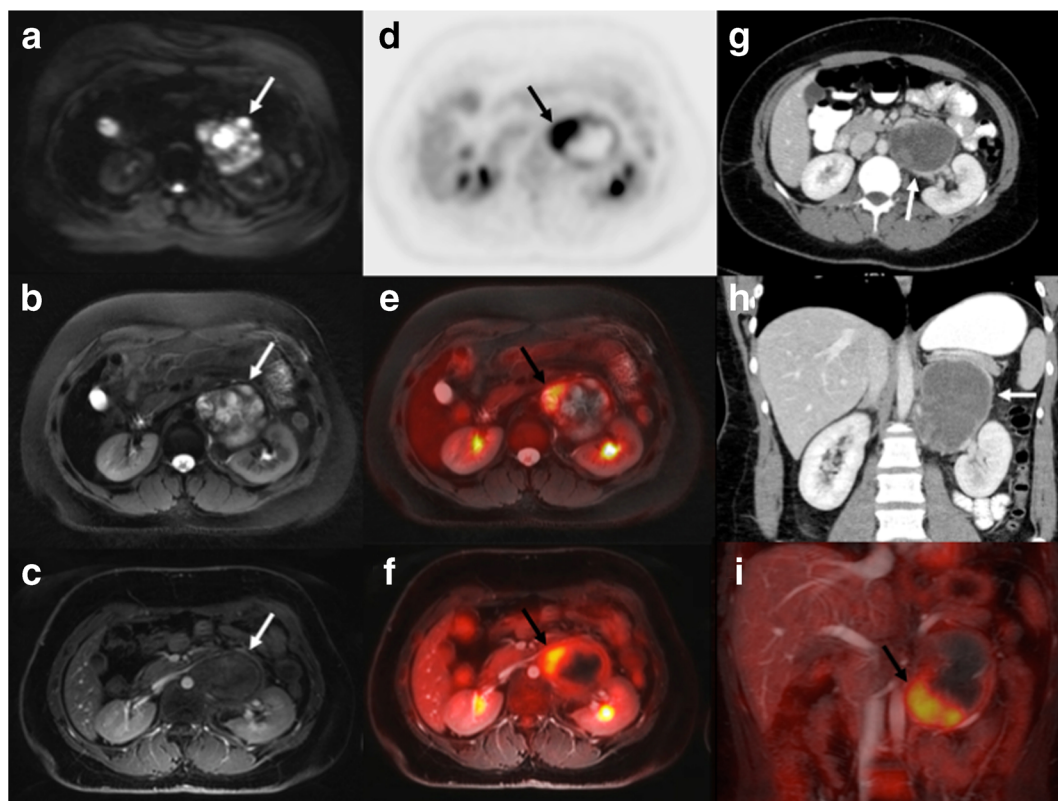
[^{18}F]FDG PET/MR and CT findings in a 25-year-old female with soft tissue sarcoma in the left retroperitoneum (arrows). a Axial diffusion weighted imaging (TR/TE/b-value: 7770/56.1/50,600) shows restricted diffusion (white arrow) of the tumor. b Axial T2 PROPELLER (TR/TE/Flip angle: 8000/95.8/142) shows inhomogeneous hyperintense tumor signal. c Ferumoxytol-enhanced T1-weighted LAVA scan (TR/TE/Flip angle: 4.2/1.7/15) shows close relation between the tumor and renal vessels. d Axial [^{18}F]FDG PET, e [^{18}F]FDG PET superimposed on T2-weighted PROPELLER scan, and f [^{18}F]FDG PET superimposed on T1-weighted LAVA scan show that the tumor contains hypermetabolic medial and caudal areas (black arrow). g, h Axial and coronal CT shows a rather featureless, slightly inhomogeneous mass (white arrow). i Coronal [^{18}F]FDG PET superimposed on T1-weighted LAVA scan again shows the hypermetabolic caudal tumor part (black arrow). At surgery, this anterior and caudal tumor part was found to be adherent to adjacent vascular structures.
